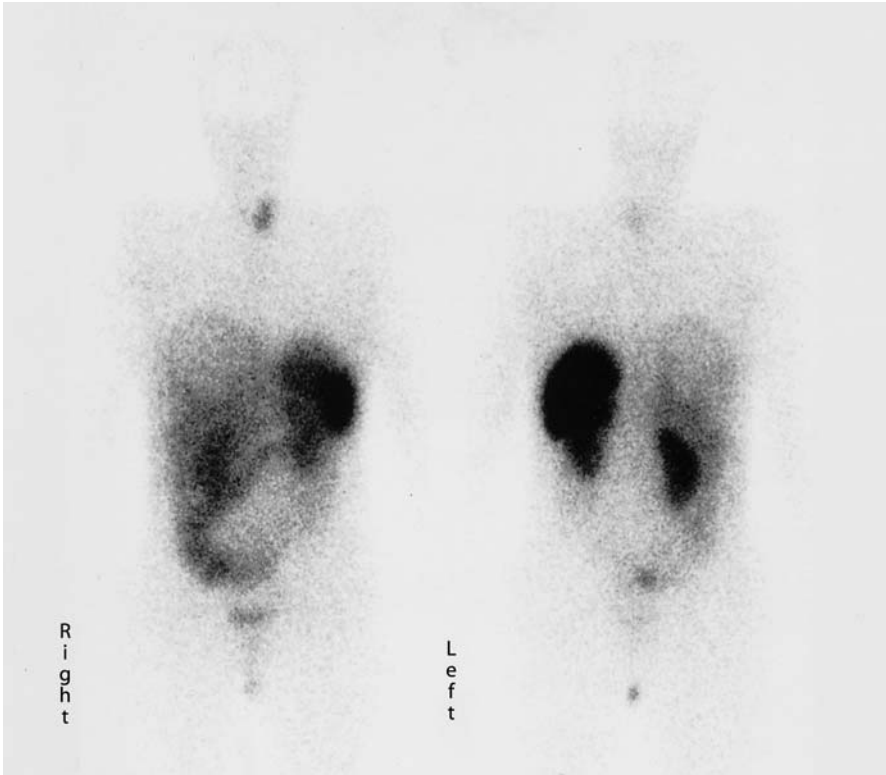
Thirty-year-old woman with primary and metastatic MTC. Somatostatin receptor scintigraphy shows good ^{111}In -DTPA-octreotide uptake in the primary tumor in the left lobe of the thyroid, but no somatostatin receptor expression in a large liver metastasis (scan at 24 h p.i.). This is in accordance with the known loss of somatostatin receptor expression in dedifferentiating MTC
